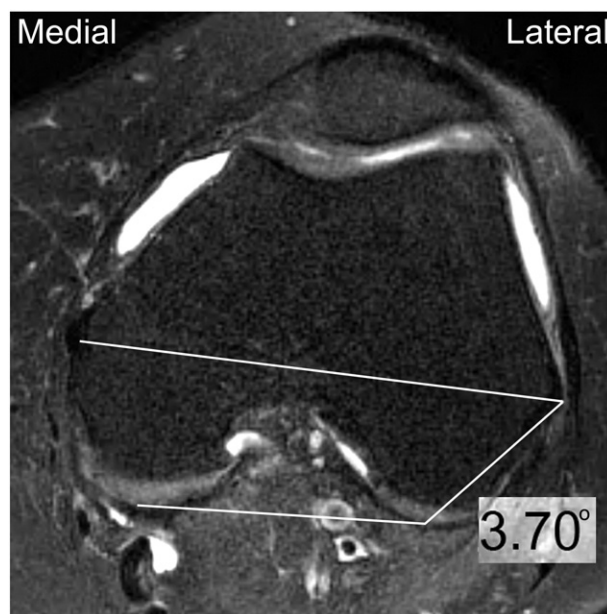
The transepicondylar axis (TEA) was drawn between the lateral epicondylar prominence and medial epicondylar sulcus, and the posterior condylar angle (PCA), or angle between it and the posterior condylar line, was measured on this T2-weighted, fat-saturated axial MRI slice.
